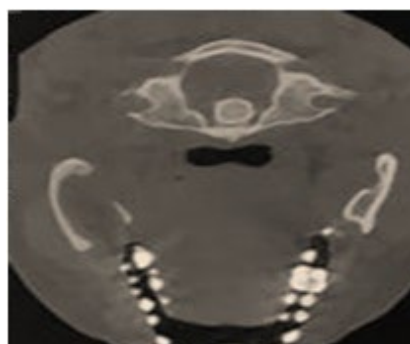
The initial cone beam. (A): 3D reconstruction revealed a radiolucent image at nearly the entire ramus. (B): The panoramic reconstruction revealed a well-defined, homogeneous radiolucent lesion, preserving the coronoid and condyloid processes. (C): The axial sections revealed the interruption of both the internal and external bone tables. (D): The oblique coronal sections revealed the close relationship of the lesion with the inferior alveolar nerve.
